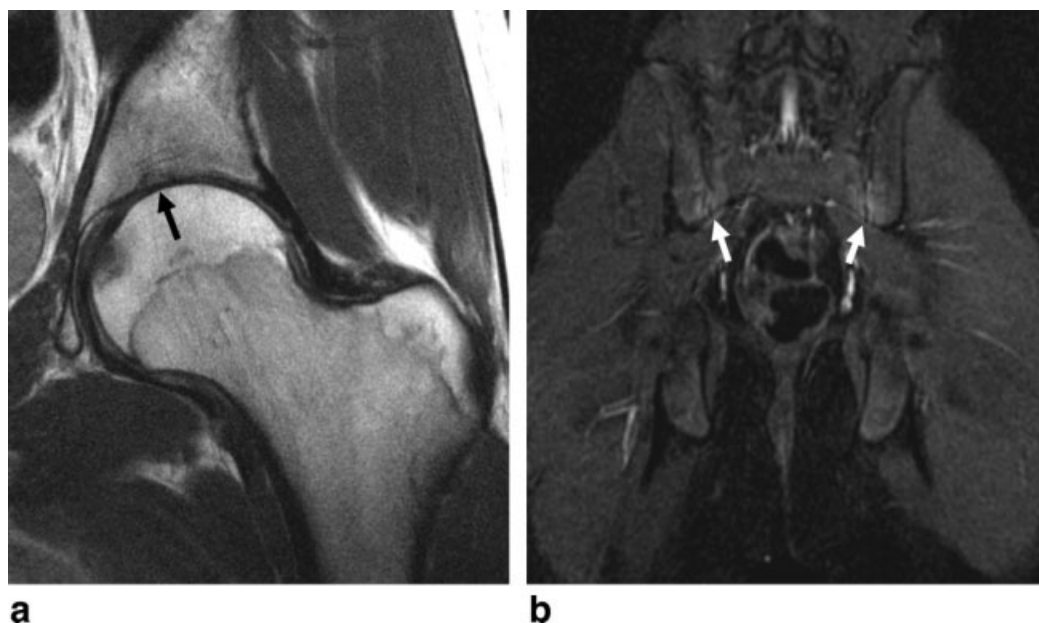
A,B: Coronal proton density (A) and STIR (B) MR images of a 17-year-old boy, requested to rule out labral tear, demonstrate inflammatory sacroiliitis (white arrows), and diffuse loss of articular cartilage (black arrow), consistent with a spondyloarthropathy. Serologic testing confirmed ankylosing spondylitis.
